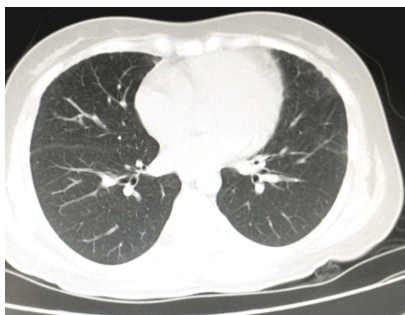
Normal CT on follow-up Lower lobe
